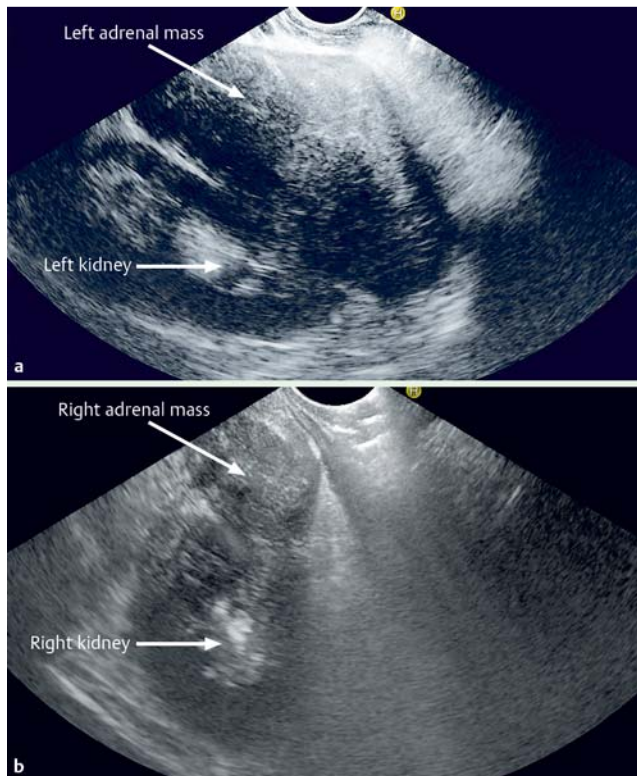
Endoscopic ultrasound images.
